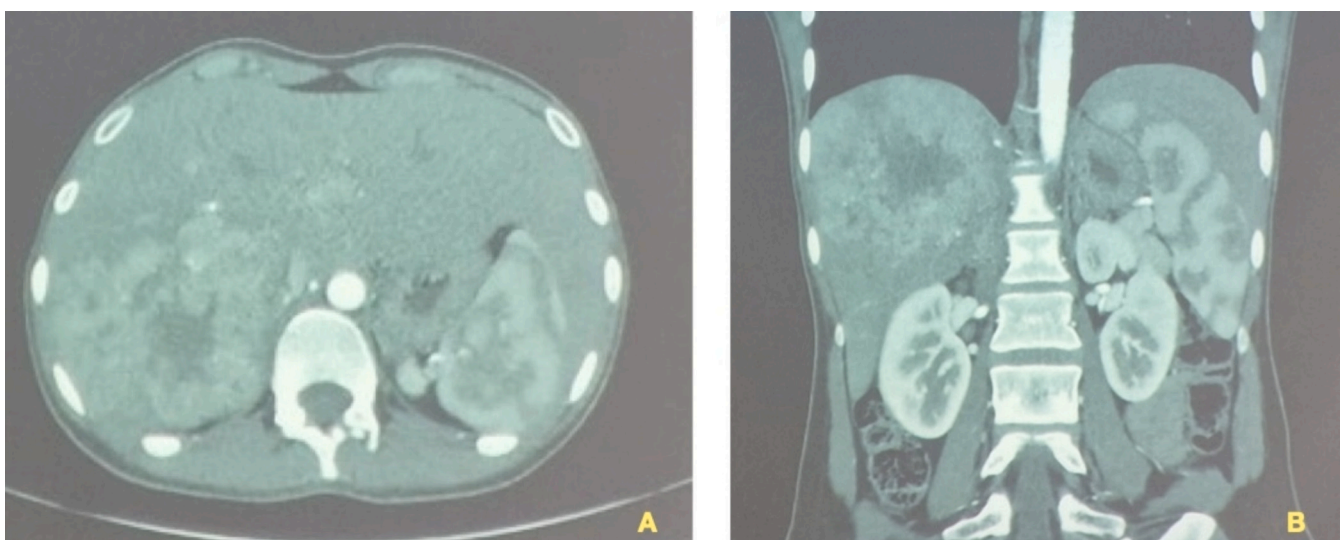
Abdominal Computed Tomography in axial (A) and coronal (B) planes showing a large tissue mass of the liver of 11 cm in diameter, straddling segments VI, VII and VIII, which presents early intense enhancement at arterial time.
